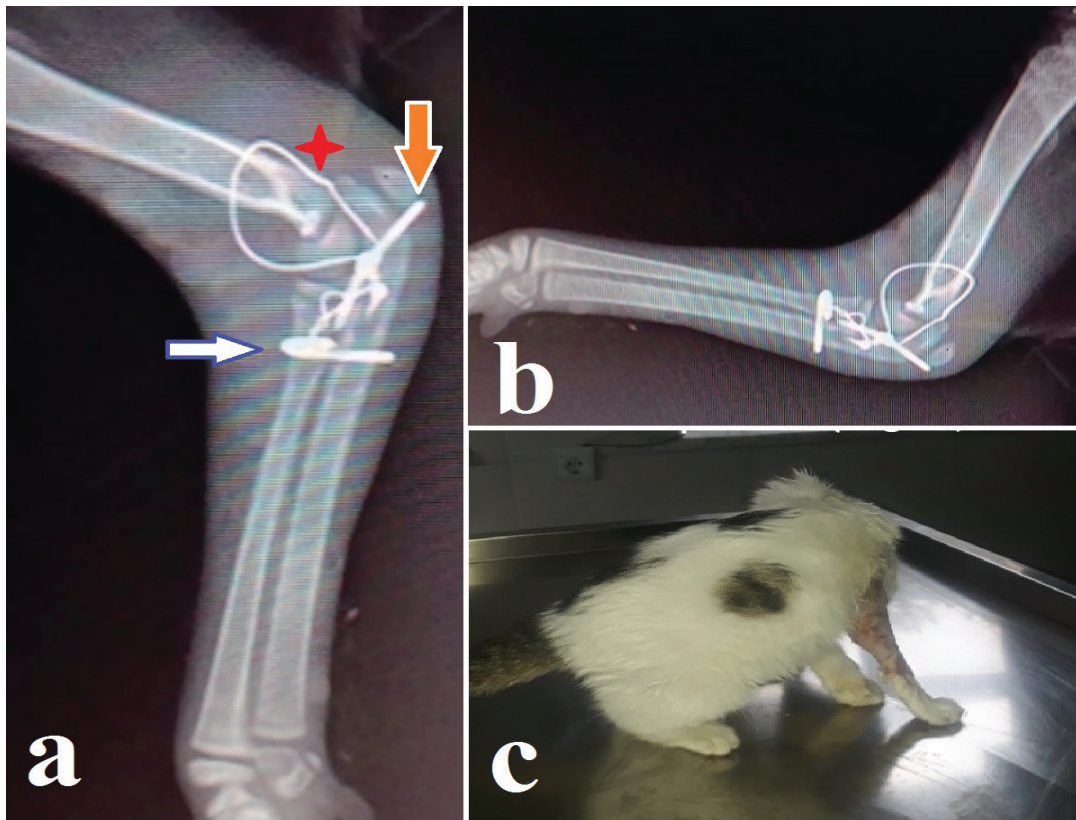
Postoperative mediolateral radiography (a,b), orthopedic nail placed between radius and ulna (white arrow), orthopedic nail placed in the olecranon (orange arrow), cerclage wire passed through the humerus and fixed to the olecranon (red star), the patient's condition on the 7th postoperative day (c).
